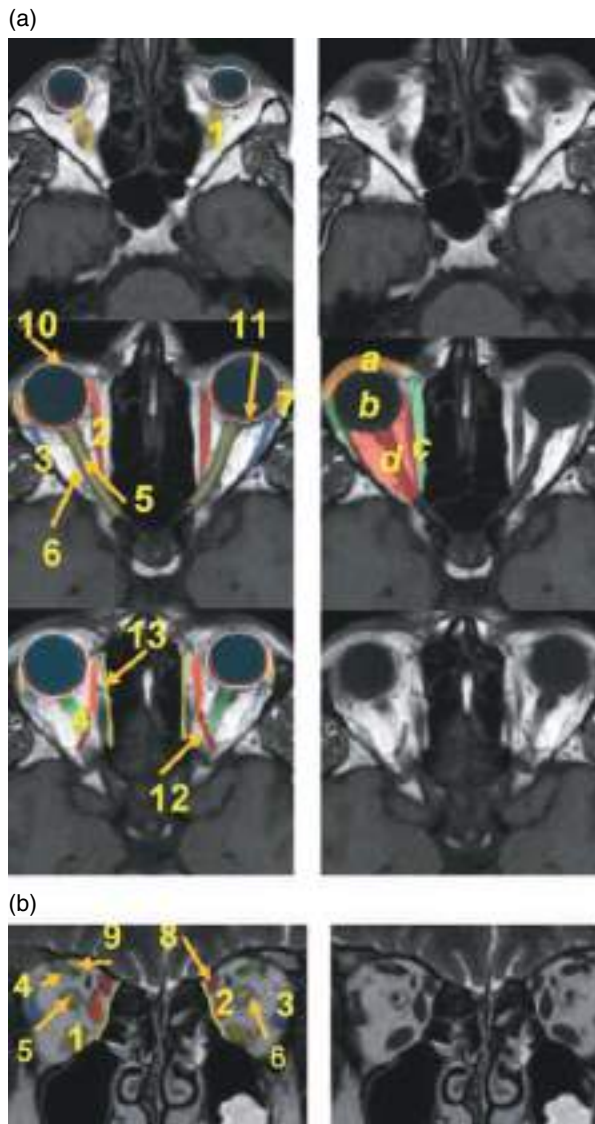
Orbit. (a) Axial T1-weighted MRI. (b) Coronal T2-weighted MRI. 1, inferior rectus muscle; 2, medial rectus muscle; 3, lateral rectus muscle; 4, superior rectus muscle; 5, optic nerve; 6, perioptic subarachnoid space; 7, lacrimal gland; 8, superior oblique muscle; 9, levator palpebrae superioris muscle; 10, sclera; 11, choroid; 12, superior ophthalmic vein; 13, lamina papyracea. Spaces of the orbit: a, preseptal space; b, ocular globe; c, extraconal space; d, intraconal space.
